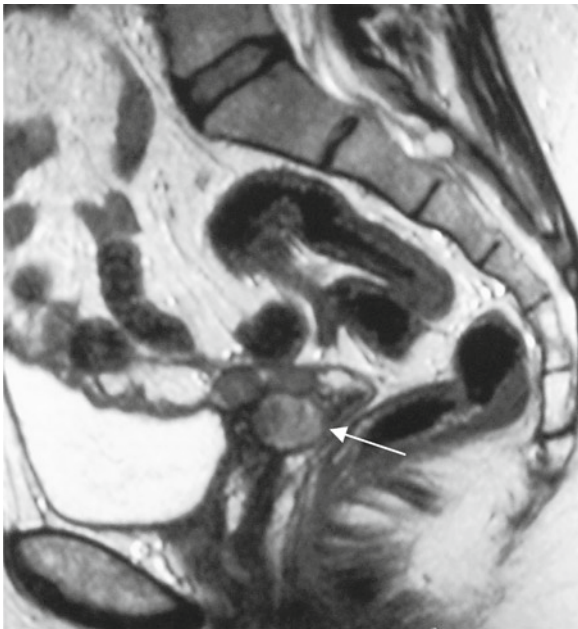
Recurrent malignant struma ovarii (thyroid carcinoma) to vaginal vault (*arrow*) post total hysterectomy and oophorectomy. Similar appearance to primary tumour, with multiple locules with different “shading” on MRI
